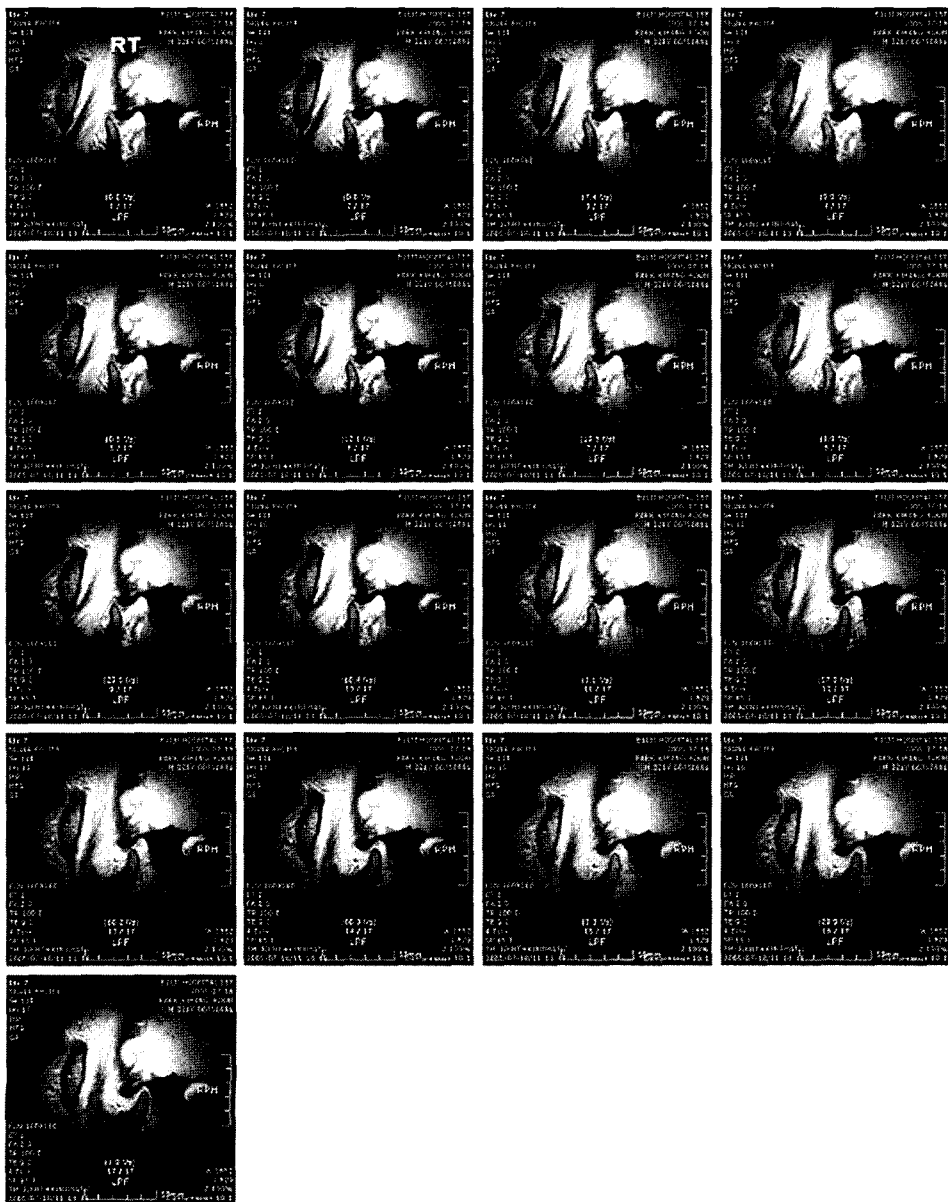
The pseudo-dynamic MRI of normal TMJ.
